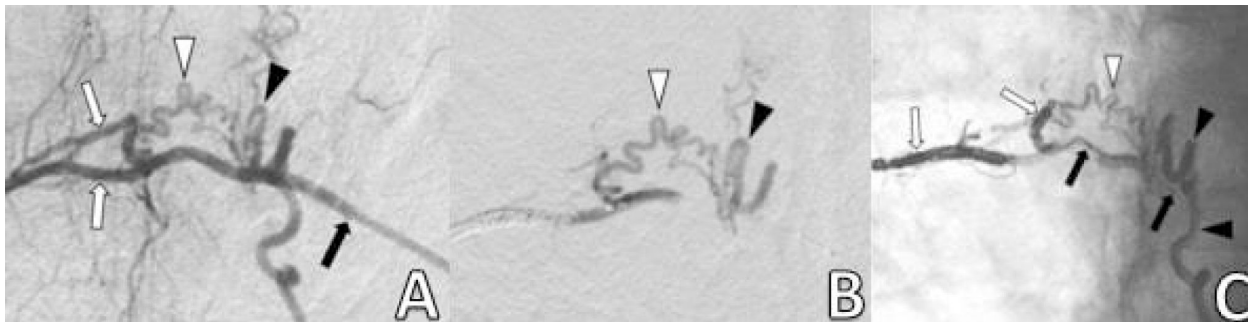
A 64-year-old male patient with newly developed urination dysfunction accompanied by progressive paraparesia for last 3 months. (A) Right T8 intercostal artery angiogram shows the segmental artery (black arrow), branches distal to the feeding artery that supply paraspinal soft tissues (white arrows), long and tortuous feeding artery of the fistula (white arrowhead), and draining vein (black arrowhead). (B) After coil embolization of the distal branches, angiogram obtained through the Scepter C balloon lumen reveals the precise anatomy of the feeding artery (white arrowhead) and proximal draining vein (black arrowhead). (C) The final roentgenogram obtained immediately after the Onyx injection shows the distal and proximal markers of the Scepter C catheter with an inflated balloon (black arrows), dens coil packing inside the distal branches (white arrows), Onyx cast inside the feeding artery (white arrowhead) and draining vein (black arrowheads).
